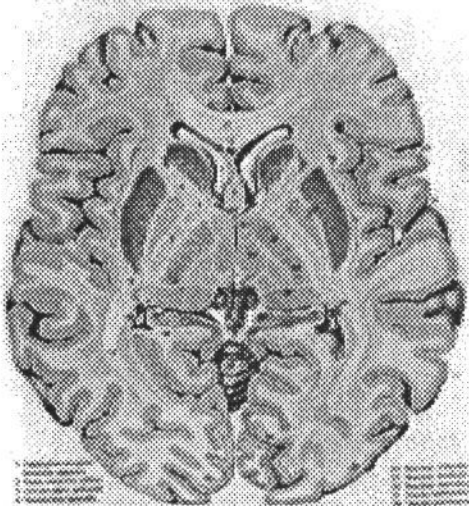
Transverse section through the striate body, the thalamus and the internal capsule corresponding to CT scan angle 0°.
